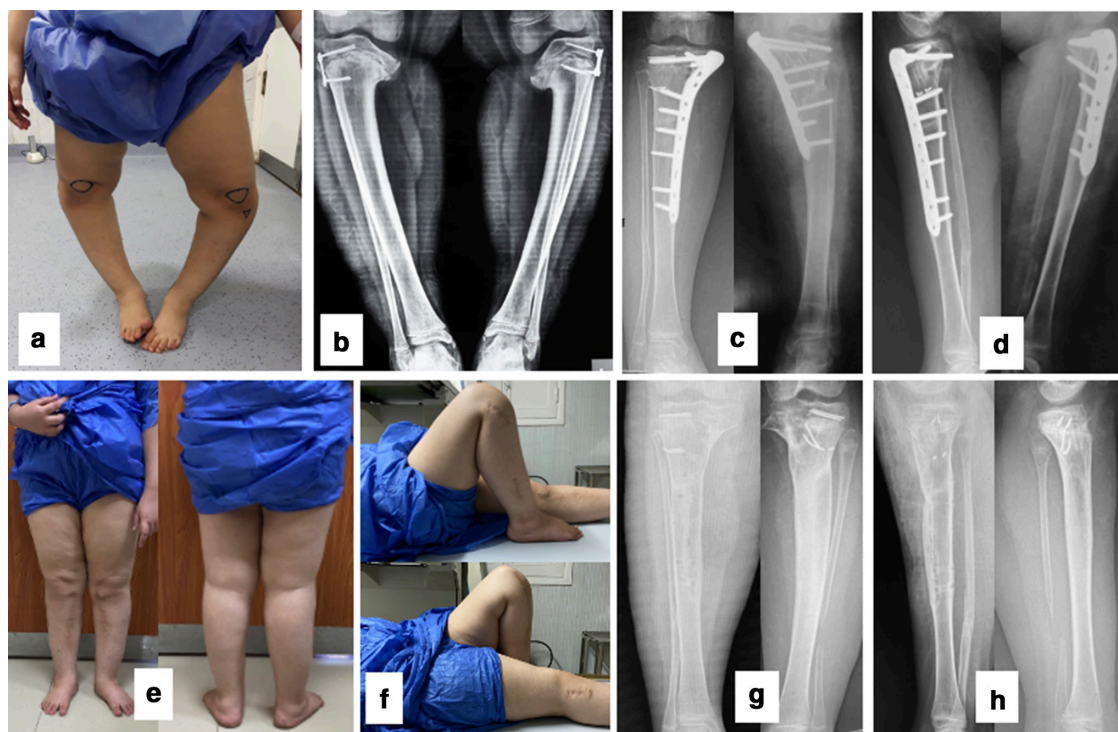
A 9.3-year-old girl with bilateral late-presenting Blount's disease: a) preoperative varus malalignment; b) bilateral advanced-stage Blount's disease with significant medial plateau depressions on standing radiographs. The patient had received a previous hemiepiphysiodesis that failed with broken screws. The screws were left in place, acting as physseal markers; c) and d) six months postoperative radiographs, all osteotomies have consolidated; e) front and back coronal and rotational alignment at four-years postoperatively; f) maintained knee flexion range of movement; g) and h) anteroposterior and lateral radiographs upon plate removal.
